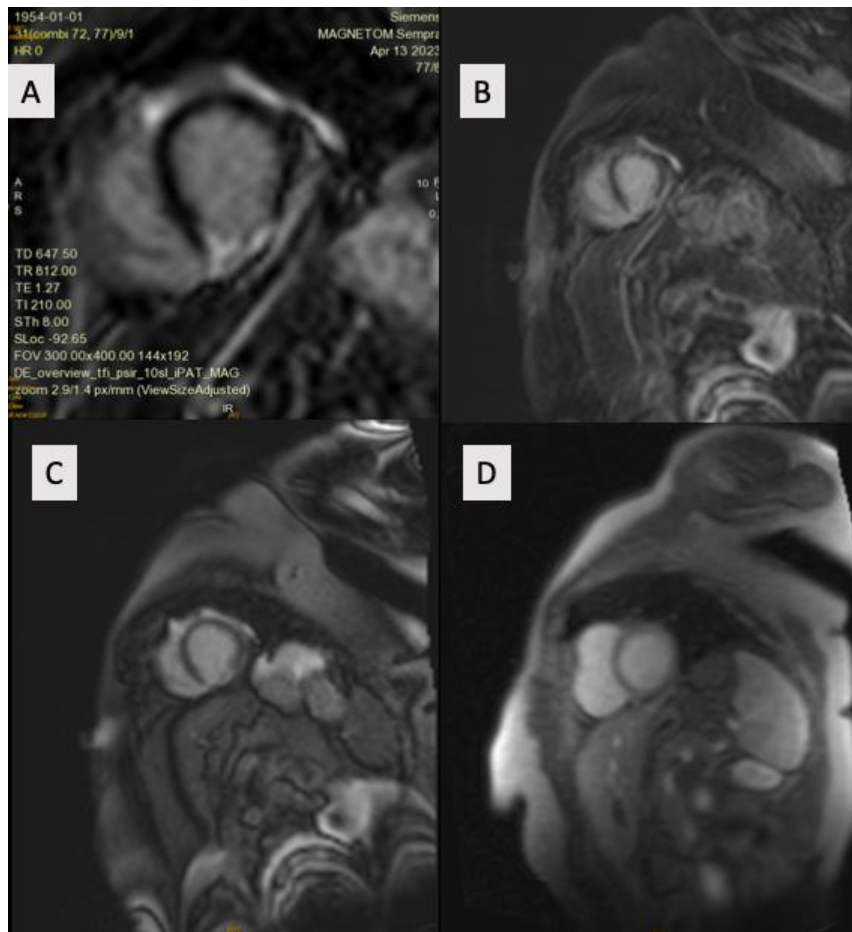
MRI loops indicate the following
